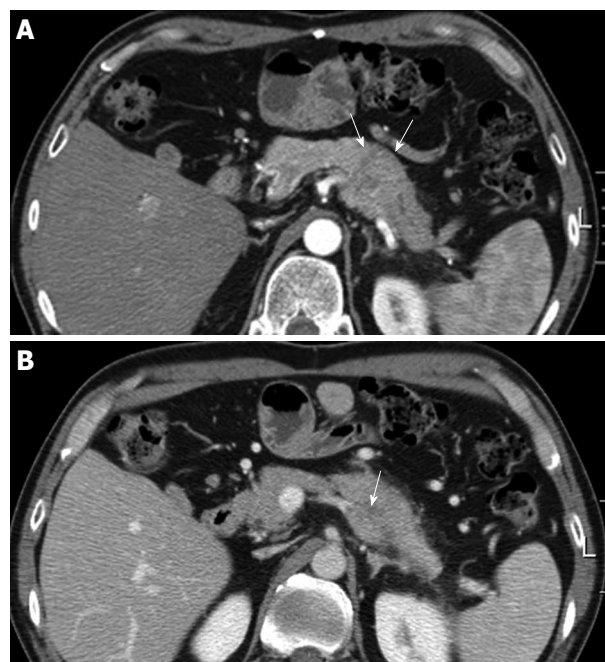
Abdominal computed tomography finding. A: Computed tomography showed an irregular mass in the tail of the pancreas that was associated with dilatation of the distal pancreatic duct (arrow); B: With a contrast-enhanced scan, the mass projected into the splenic vein (arrow).
